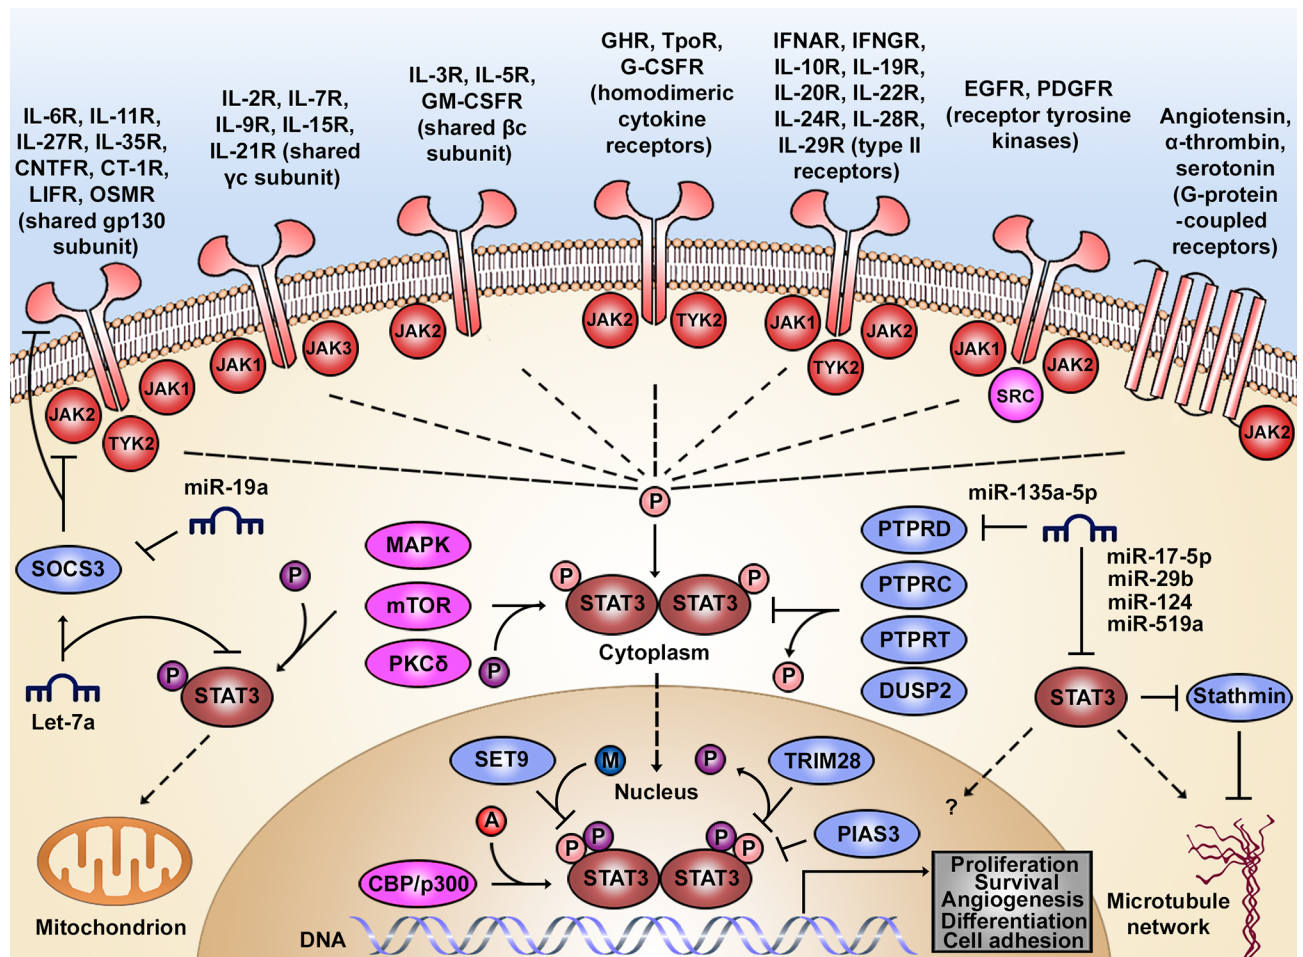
Regulatory circuits of the STAT3 signaling pathway. STAT3 can be activated by a wide range of ligands binding to cytokine, growth factor, or G-protein-coupled receptors. With the exception of receptor tyrosine kinases, these receptors lack intrinsic kinase activity and thus act by recruiting adaptor kinases (e.g., JAKs, SRC) to propagate downstream signals. As a result, STAT3 is phosphorylated at tyrosine 705 (pY705, pink), forms homodimers or heterodimers, and translocates to the nucleus, where it transcribes regulators of various cellular processes. Additionally, STAT3 can be phosphorylated at serine 727 (pS727, purple) by serine/threonine kinases (e.g., MAPK, mTOR, PKCδ), which enhance STAT3 transcriptional activity in the nucleus or direct STAT3 to mitochondria. Acetylation at lysine 685 (K685, red) by histone acetyltransferases (e.g., CREB binding protein CBP/histone acetyltransferase p300) or methylation at lysine 140 (K140, blue) by histone methyltransferases (e.g., SET9) favor or impair STAT3 transcriptional activity, respectively. Unphosphorylated STAT3 exhibits regulatory functions in the nucleus or can be retained in the cytoplasm, where it associates with microtubules and focal adhesions. The activity of STAT3 is tightly regulated by phosphatases (e.g., PTPRD), SOCS3, PIAS3, and miRNAs that fine-tune the temporal pattern of STAT3 activity and its other pathway components. All miRNAs are degrading the mRNAs of the indicated proteins. A, acetylation; CBP, CREB-binding protein; CT-1R, ciliary neurotrophic factor receptor; DUSP2, dual specificity protein phosphatase 2; EGFR, epidermal growth factor receptor; GHR, growth hormone receptor; G-CSFR, granulocyte colony-stimulating factor receptor; GM-CSFR, granulocyte-macrophage colony-stimulating factor receptor; gp130, glycoprotein 130; IFNAR, interferon alpha receptor; IFNGR, interferon gamma receptor; IL, interleukin; JAK, Janus kinase; K140, lysine 140; K685, lysine 685; LIFR, leukemia inhibitory factor receptor; MAPK, mitogen-activated protein kinase; M, methylation; miRNA, microRNA; mTOR, mechanistic target of rapamycin; OSMR, oncostatin-M-specific receptor; P, phosphorylation; p300, histone acetyltransferase p300; PDGFR, platelet-derived growth factor receptor; PIAS3, protein inhibitor of activated STAT protein 3; PKCδ, protein kinase C delta type; pS727, phosphoserine 727; PTPRC, receptor-type tyrosine-protein phosphatase C; PTPRD, receptor-type tyrosine-protein phosphatase D; PTPRT, receptor-type tyrosine-protein phosphatase T; pY705, phospho-tyrosine 705; SET9, histone-lysine N-methyltransferase SET9; SOCS3, suppressor of cytokine signaling 3; SRC, proto-oncogene tyrosine-protein kinase; STAT3, signal transducer and activator of transcription 3; TpoR, thrombopoietin receptor; TRIM28, tripartite motif-containing protein 28.
